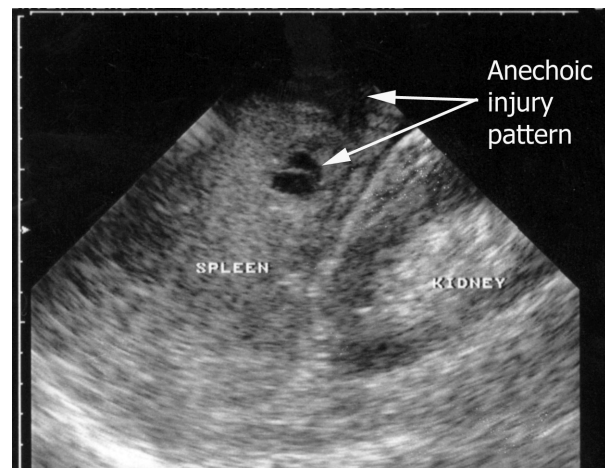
Ultrasound image demonstrating disruption of the splenic architecture representing solid organ injury.
